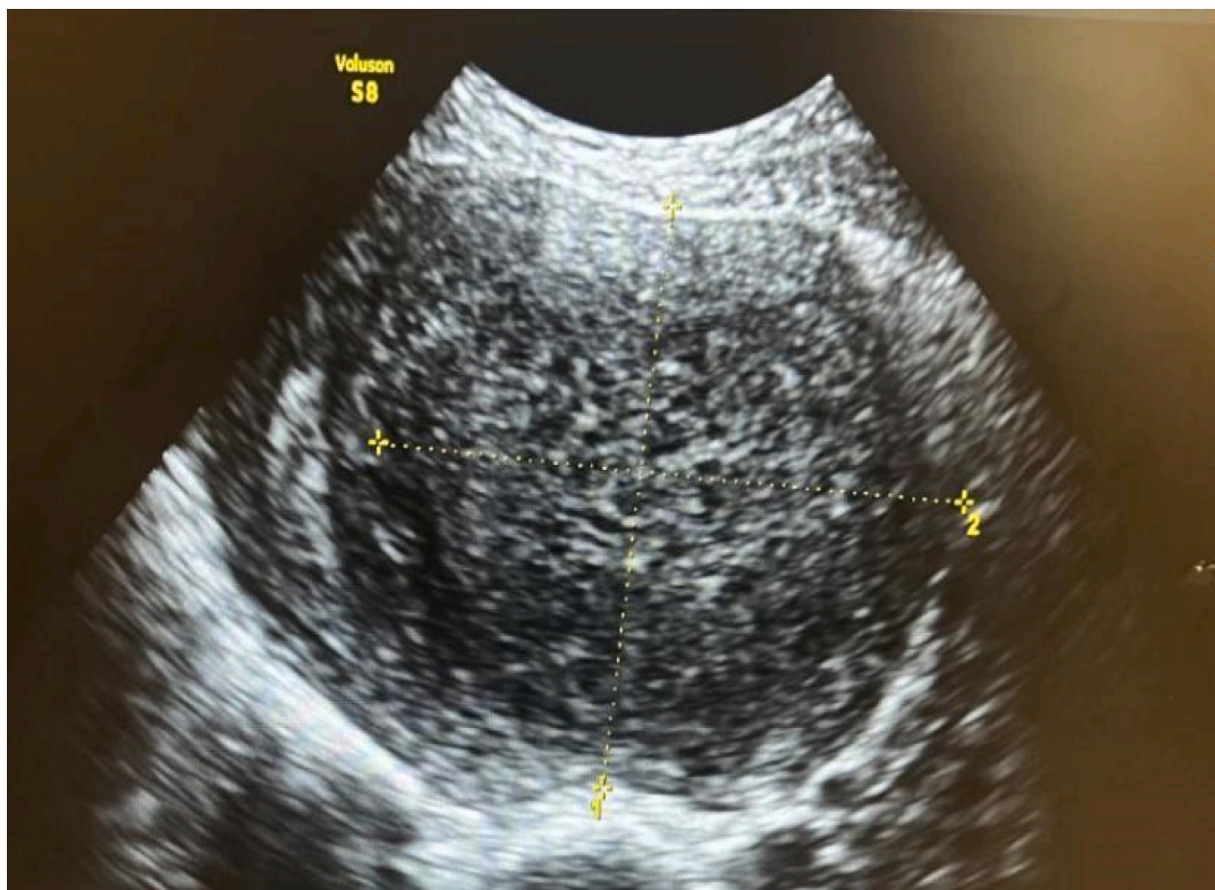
Transvaginal ultrasound demonstrating an enlarged uterus with a well-circumscribed, heterogeneous lesion in the myometrium measuring 9.8 × 8.7 cm.
